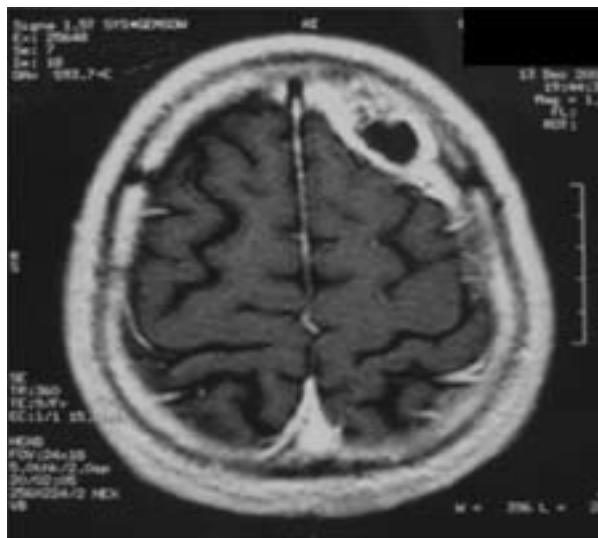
Enhanced T1-weighted magnetic resonance image showing a 5-cm epidural collection with adjacent osteolytic lesions in the left frontal area.
